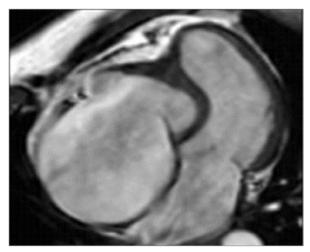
Magnetic resonance image shows severe tricuspid valve insufficiency, severe right ventricular apical hypoplasia, and a severely dilated right atrium.
